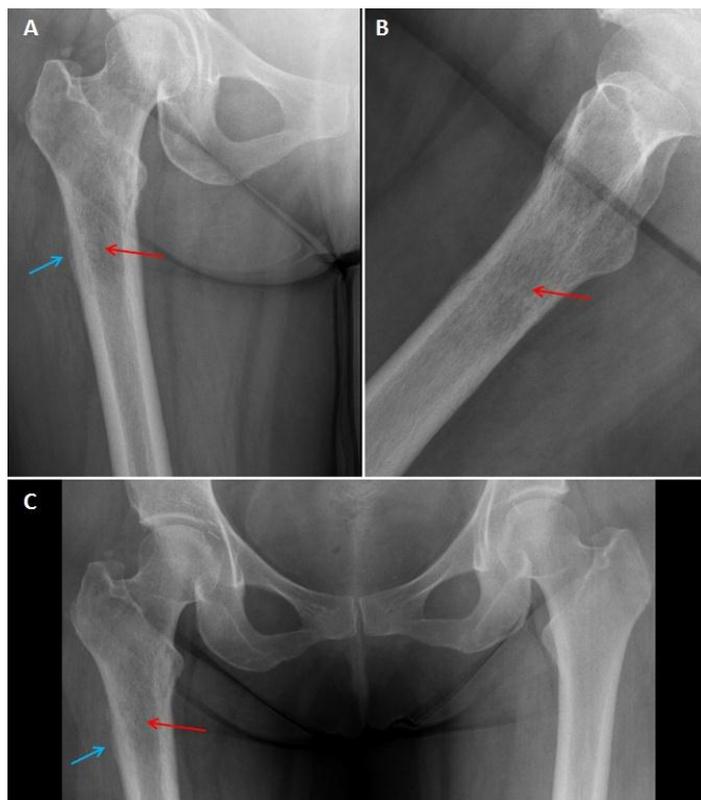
(left): 43 year old female with malignant phyllodes tumor. Femur radiographs.
